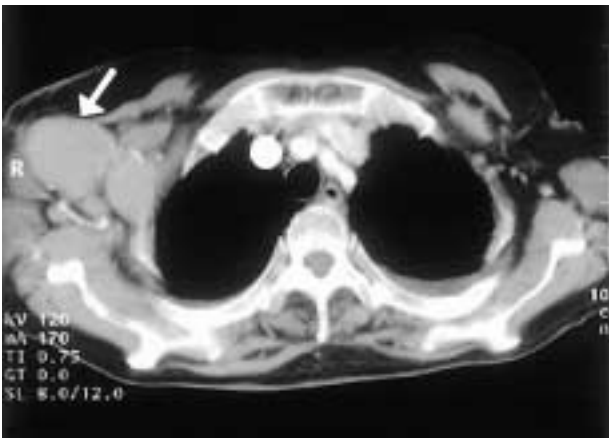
Chest CT scan showing well-defined hypodense masses (arrow) in the right axillary region.
